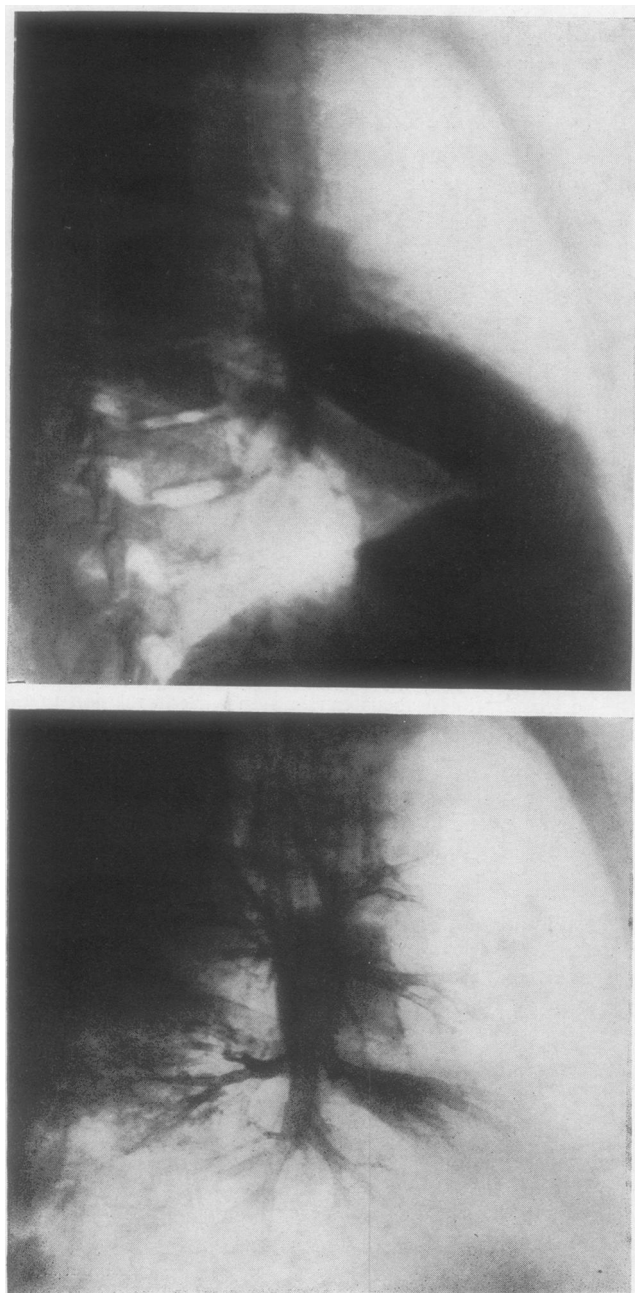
Case 1; radiograph shows consolidation of the middle lobe, and the bronchogram a sessile filling defect in the floor of the middle lobe bronchus; biopsy demonstrated tuberculous granulation tissue.
